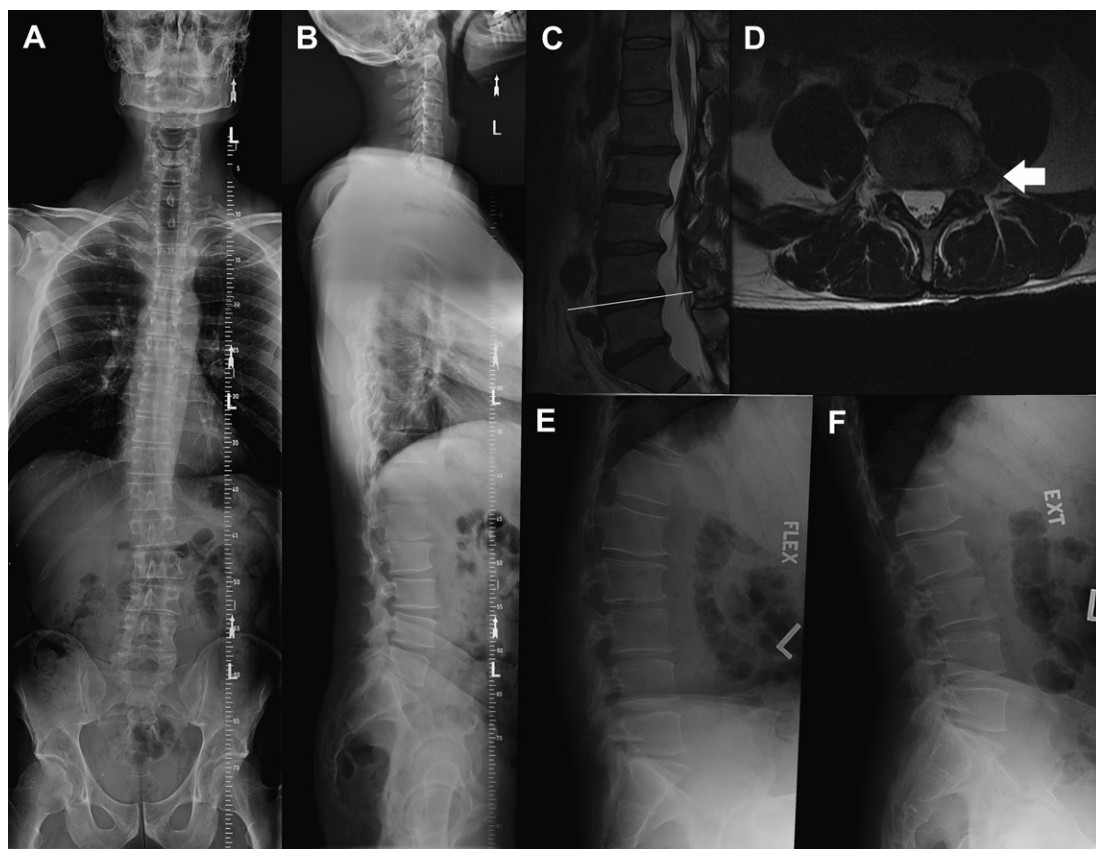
A 46-year-old man presented with a left leg radiculopathy. He did not have back pain. (A, B) 91.44-cm (36-in) radiographs show mild thoracolumbar scoliosis and maintained sagittal balance. (C, D) Sagittal and axial T2-weighted MRI reveals a far lateral disk herniation (arrow) at the left L4/5 level. (E, F) Flexion and extension radiographs did not show any instability. This patient had a minimally invasive far lateral discectomy without instrumentation (MiSLAT I treatment).
